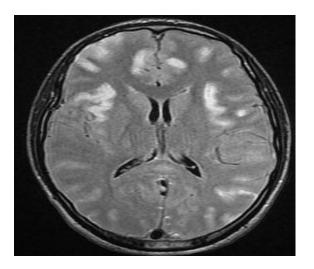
Axial T2-weighted FLAIR slices showing diffuse cortical and subcortical hyper intensity lesions of the island, frontal and left occipital lobes.
